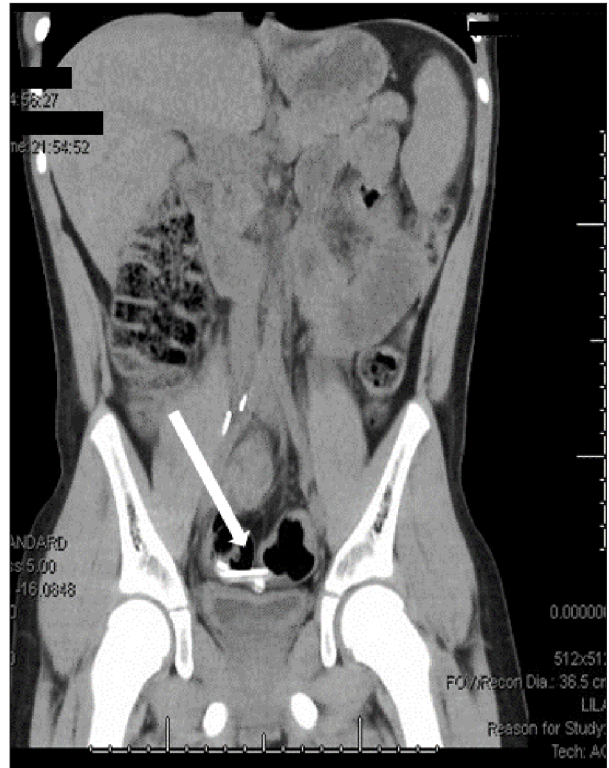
Abdominal CT scan coronal view showing the entry of PD catheter in sigmoid colon (arrows).
